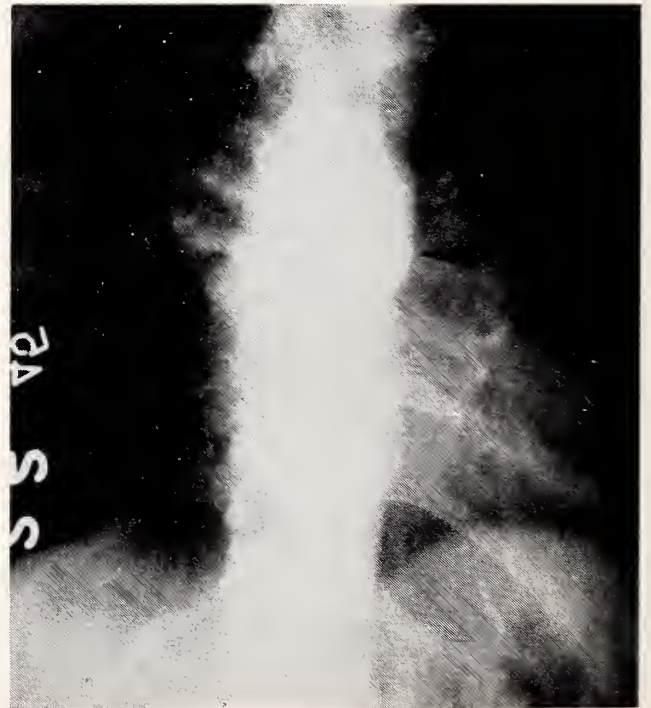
Tuberculosis involving spine (Pott's disease). P-A roentgenogram showing paraspinous mass.
